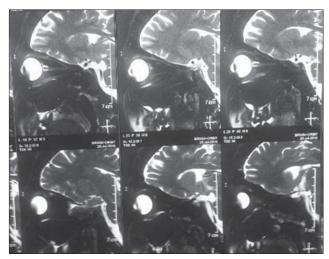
Magnetic resonance imaging of the brain and orbit showing no significant changes
